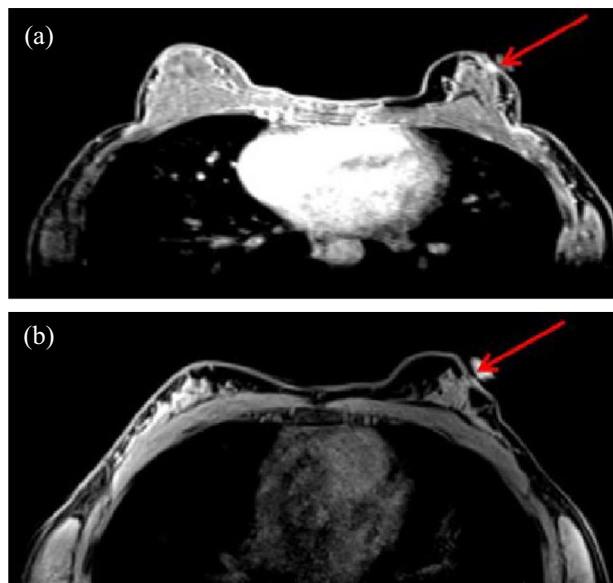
Magnetic resonance image of patient in 2014. Vitamin marker E overlies the left upper breast and shows the site of the prior lumpectomy. The red arrow (superimposed on vitamin E marker) indicates the area of subtle architectural distortion without abnormal enhancement. (B) Magnetic resonance image from 2016 with a 0.6 cm area of subcutaneous enhancement that is contiguous with the postsurgical scar.
